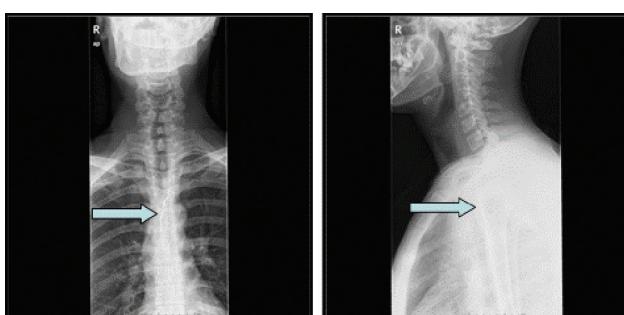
Radiopaque hook of the dental prosthesis at the mid-esophageal level on the chest X-ray.
